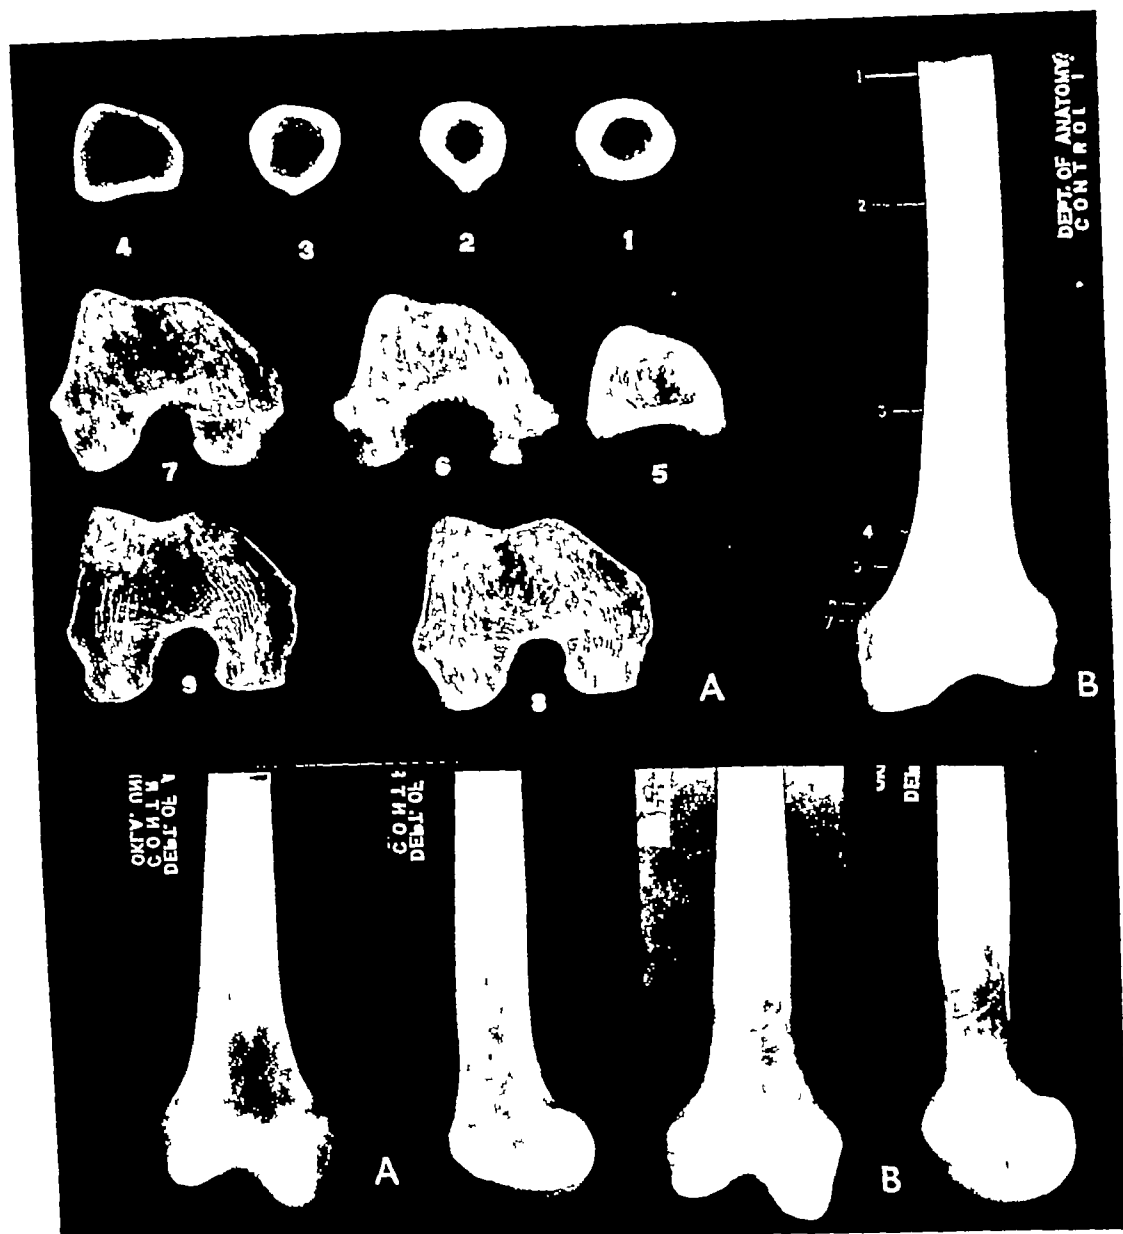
A (upper) Roentgenograms of horizontal sections through shaft and distal end of femur. In the horizontal sections the lateral condyle is on the left, the medial on the right. Figures in B indicate levels of sections.
